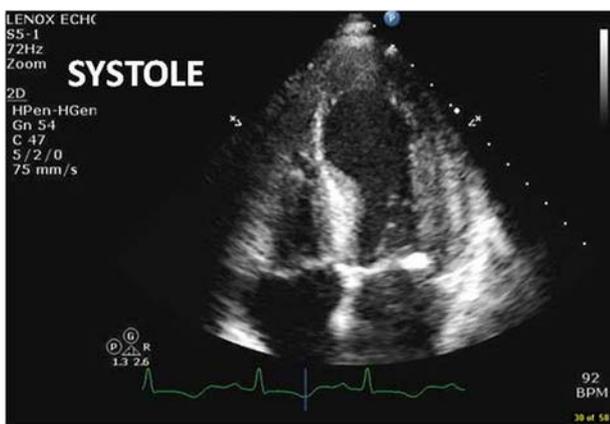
Echocardiogram showing the left ventricle during systole with akinesis of the apex and hyperactive basal segments, giving the appearance of an 'octopus trap'.
